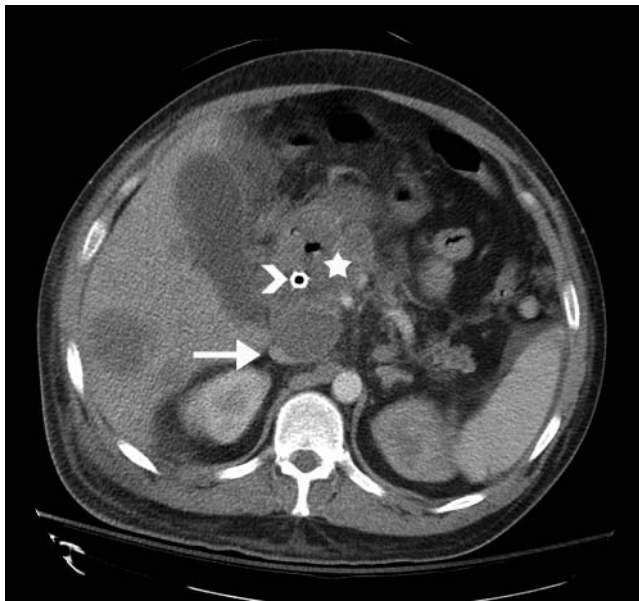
A 36-year-old male with metastatic pancreatic cancer undergoing palliative care presented with gross bilateral lower limb painful edema. Duplex ultrasonography showed no evidence of deep vein thrombosis. An axial multidetector computed tomographic scan acquired in the portovenous phase demonstrates a metal biliary stent (arrowhead) in situ passing through the large pancreatic malignancy (star). There is marked anterior extrinsic compression of the inferior vena cava by the pancreatic tumor, with only a small residual caval lumen remaining (arrow).
